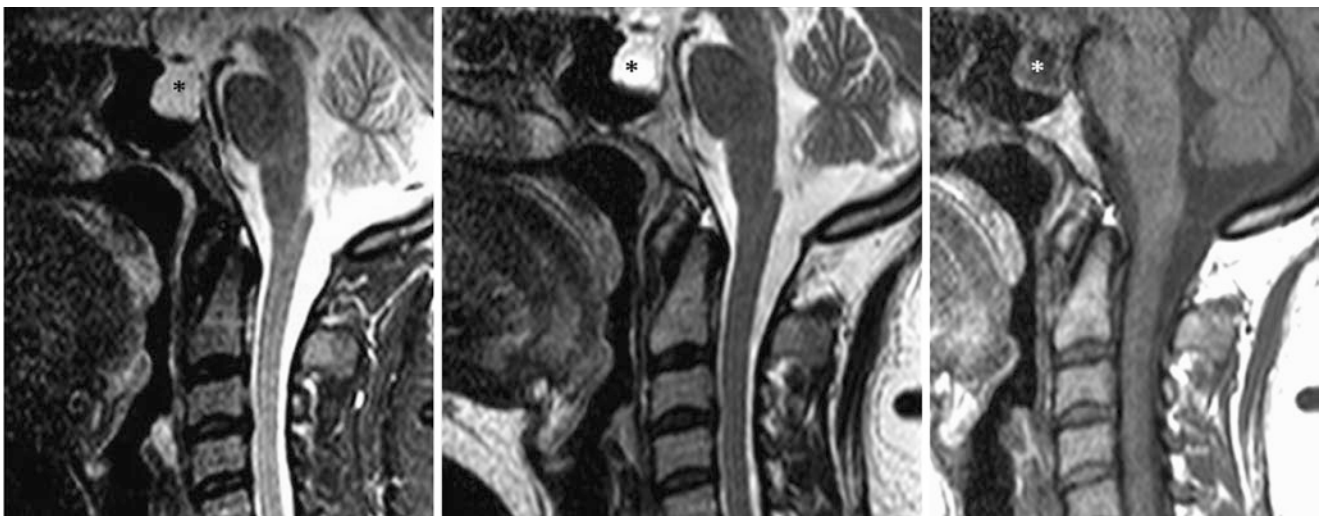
A 44-year-old female patient with neck pain had a completely empty PES (*) noted incidentally at the top of a cervical 1.5 T MRI. The bony contour of the sella is mildly enlarged. The stalk was not visible on sagittal STIR (*left*), T2WI (*middle*), or on noncontrast T1WI (*right*)
